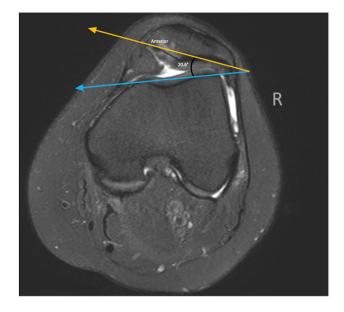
Patellar Tilt. Axial T2-weighted MRI of a right knee demonstrating lateral patellar tilt evaluated by measuring the angle between the anterior condylar line (blue line) and a line through the maximum width of the patella (yellow line). Patellar instability is often associated with a patellar tilt angle greater than 20 degrees
